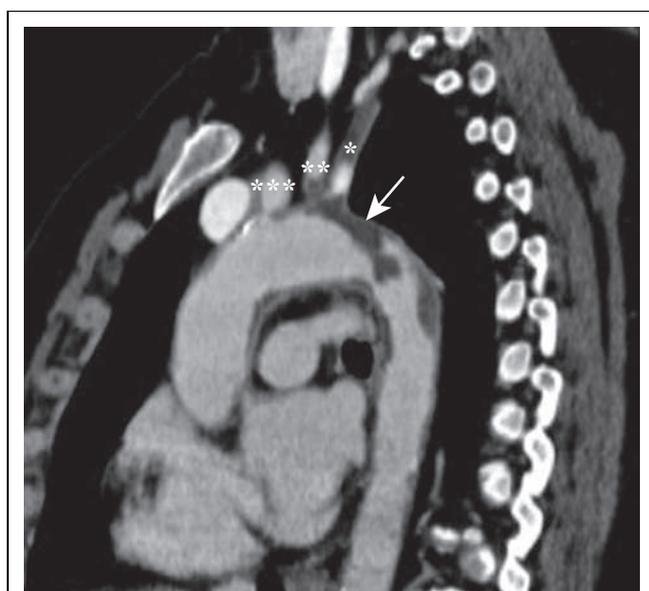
Computed tomography angiography (CTA) showing a “floating” thrombus in the aortic arch and proximal descending thoracic aorta. Permission to reproduce granted from Elsevier *J Vasc Surg*.⁶⁴⁹
